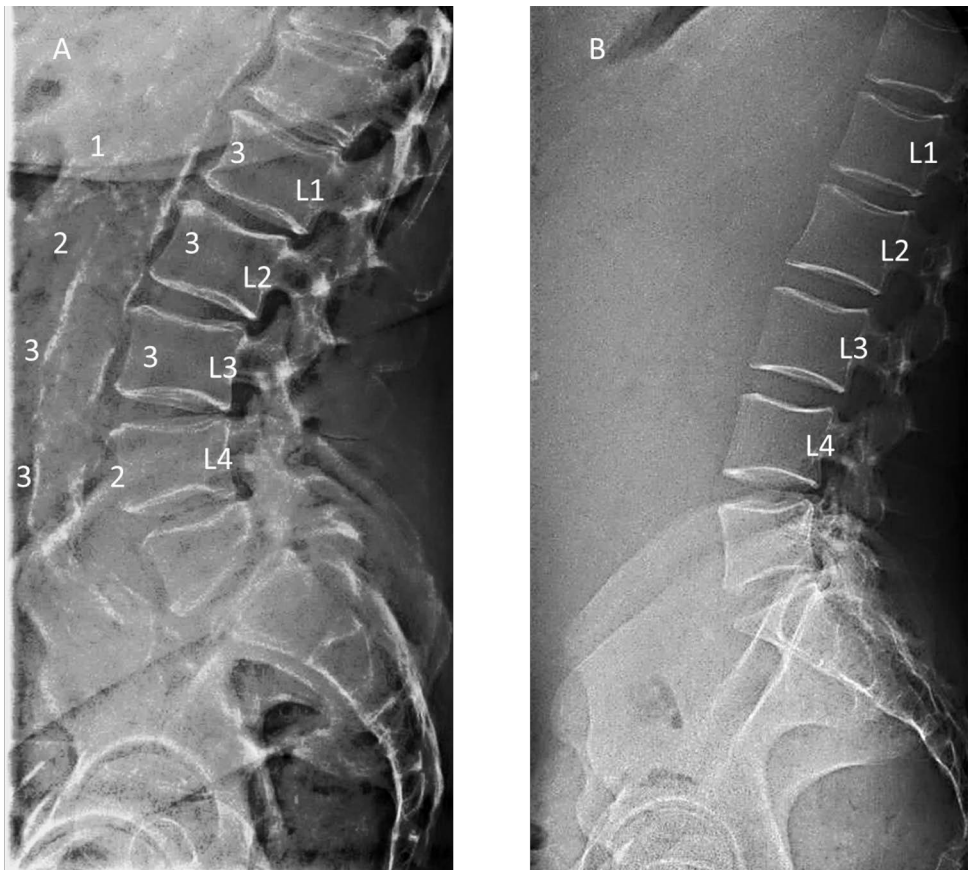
Example of the abdominal aortic calcification assessment from a plain lateral lumbar radiograph. A) Severe calcification, AAC score 20/24 in a 60-year-old male with CKD 5. B) No calcific deposits, AAC score 0/24 in a 40-year-old woman with CKD 5. (Lankinen et al. 2021). Reproduced with the permission of Creative Commons licence.
